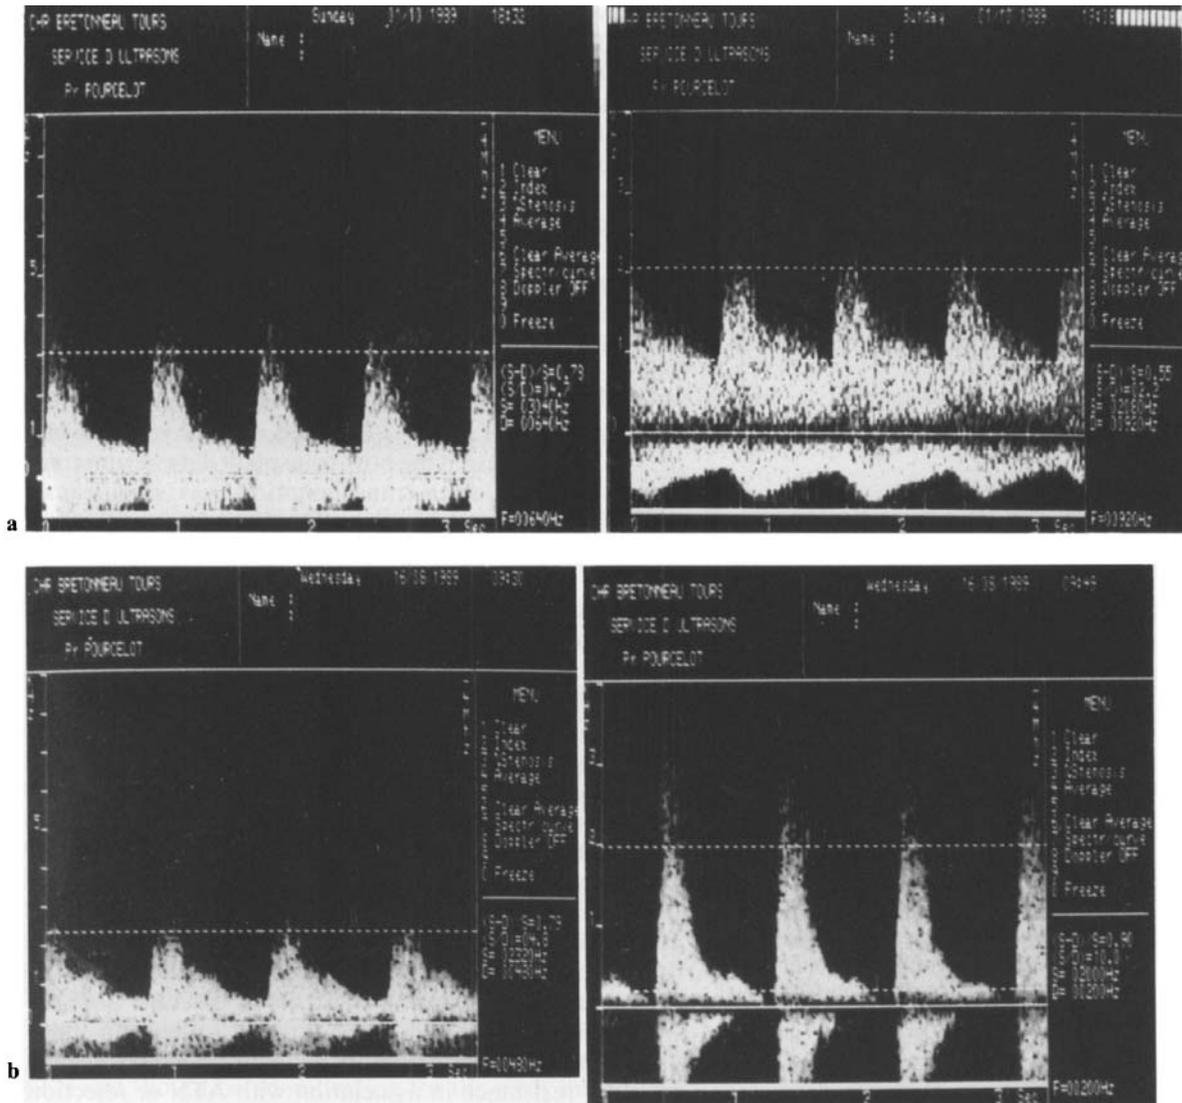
Doppler waveform recordings from renal artery after unclamping. a Without ATN at 2 min (left), at 30 min (right); b with ATN at 2 min (left), at 30 min (right)
